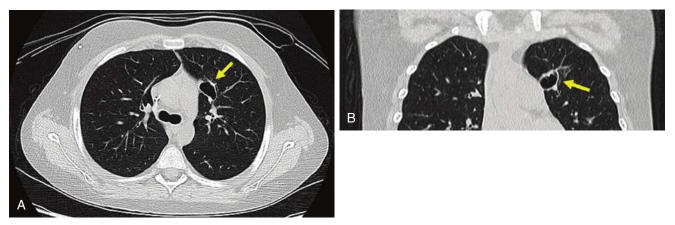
Targeted low-dose CT of the upper chest of a 12-year-old for follow-up of left upper lobe cavity (arrow); effective dose, 0.5 mSv. A, Axial image; B, coronal reformatted image.
